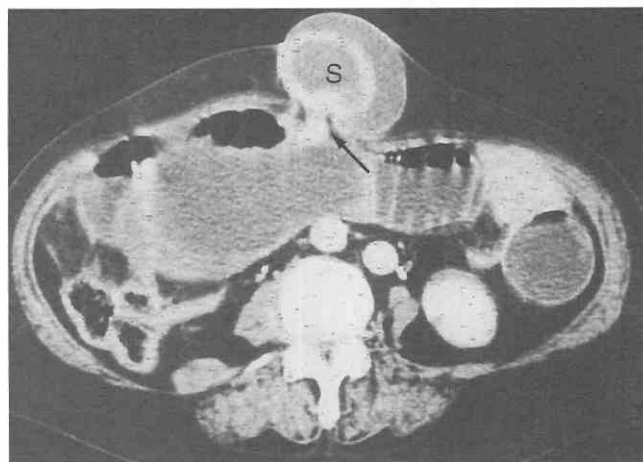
Incisional external hernia with intestinal strangulation. CT scan shows marked enhancement of a small-bowel loop (S) herniated in the hernia sac along with a narrowed hernia neck (arrows). Fluid collection is present in the hernia sac.
